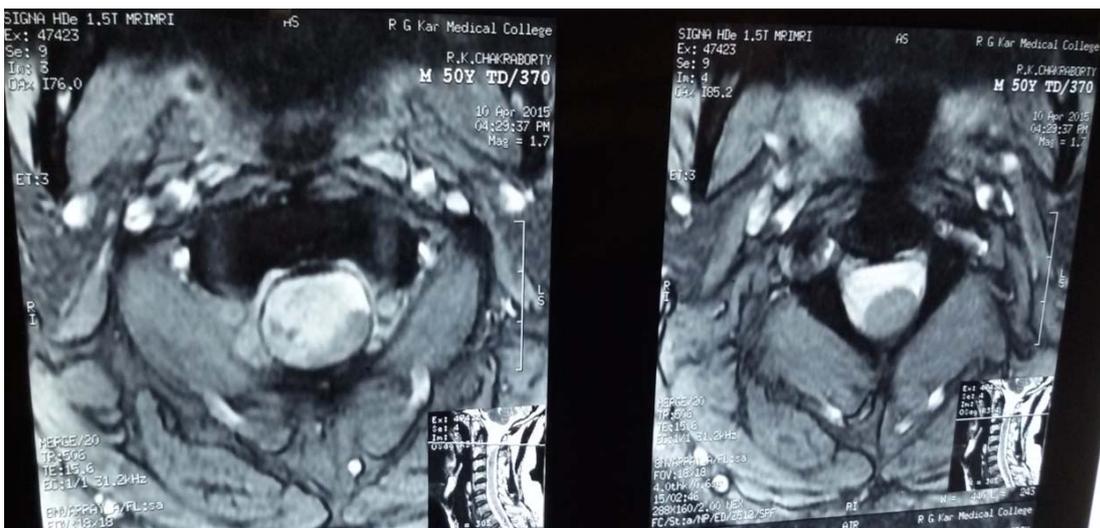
Pre-op axial T2-MRI
